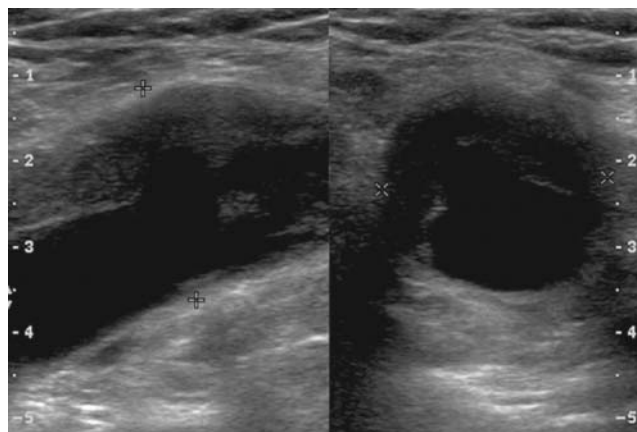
Repair of popliteal artery aneurysms. Ultrasonographic examination of the right popliteal artery demonstrates a 2.6 cm right popliteal artery aneurysm, shown in both sagittal (*left*) and transverse (*right*) views.
